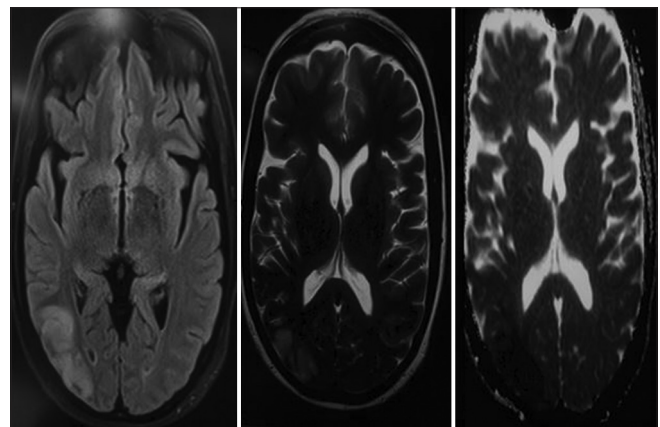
There is evidence of T2, FLAIR hyperintensity with diffusion restriction involving right occipital cortex, suggestive of atypical posterior reversible encephalopathy syndrome
